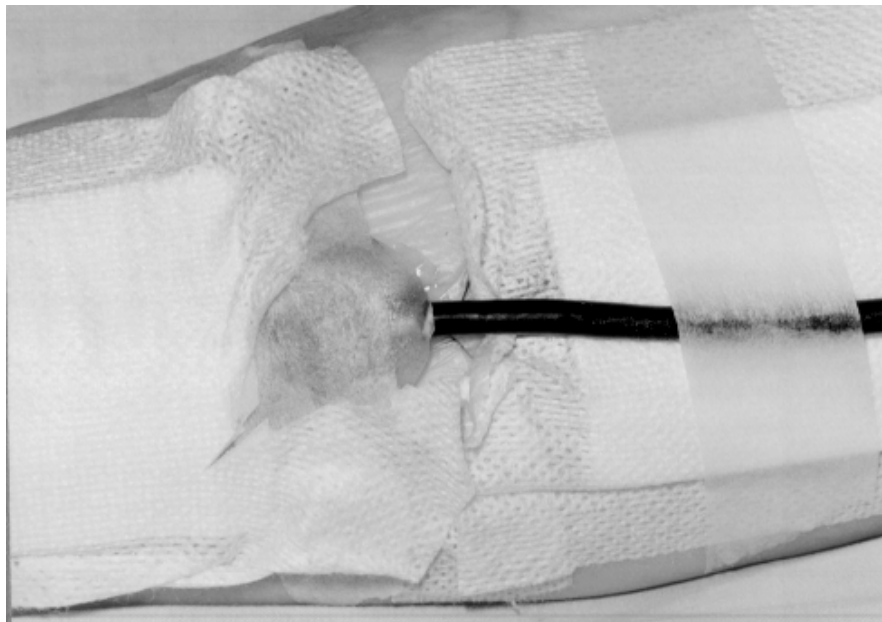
Purpose built ultrasonic CW doppler probe attached to a patient.
